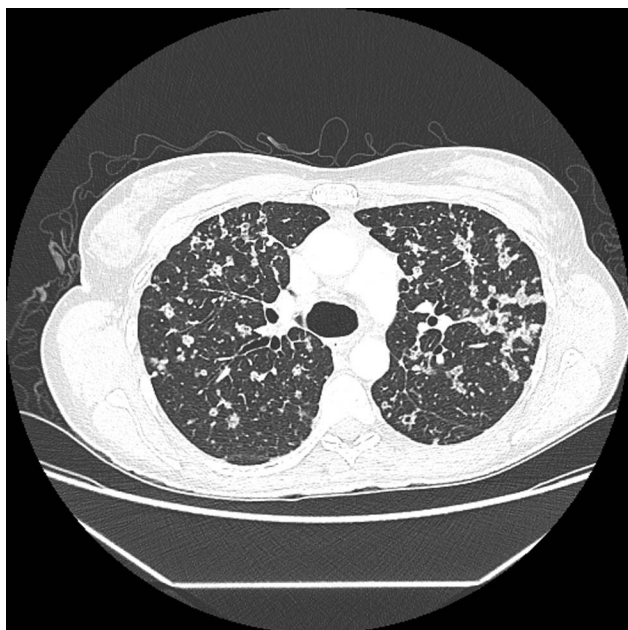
High-resolution computed tomography of the chest confirming poorly defined cavitating nodules.
